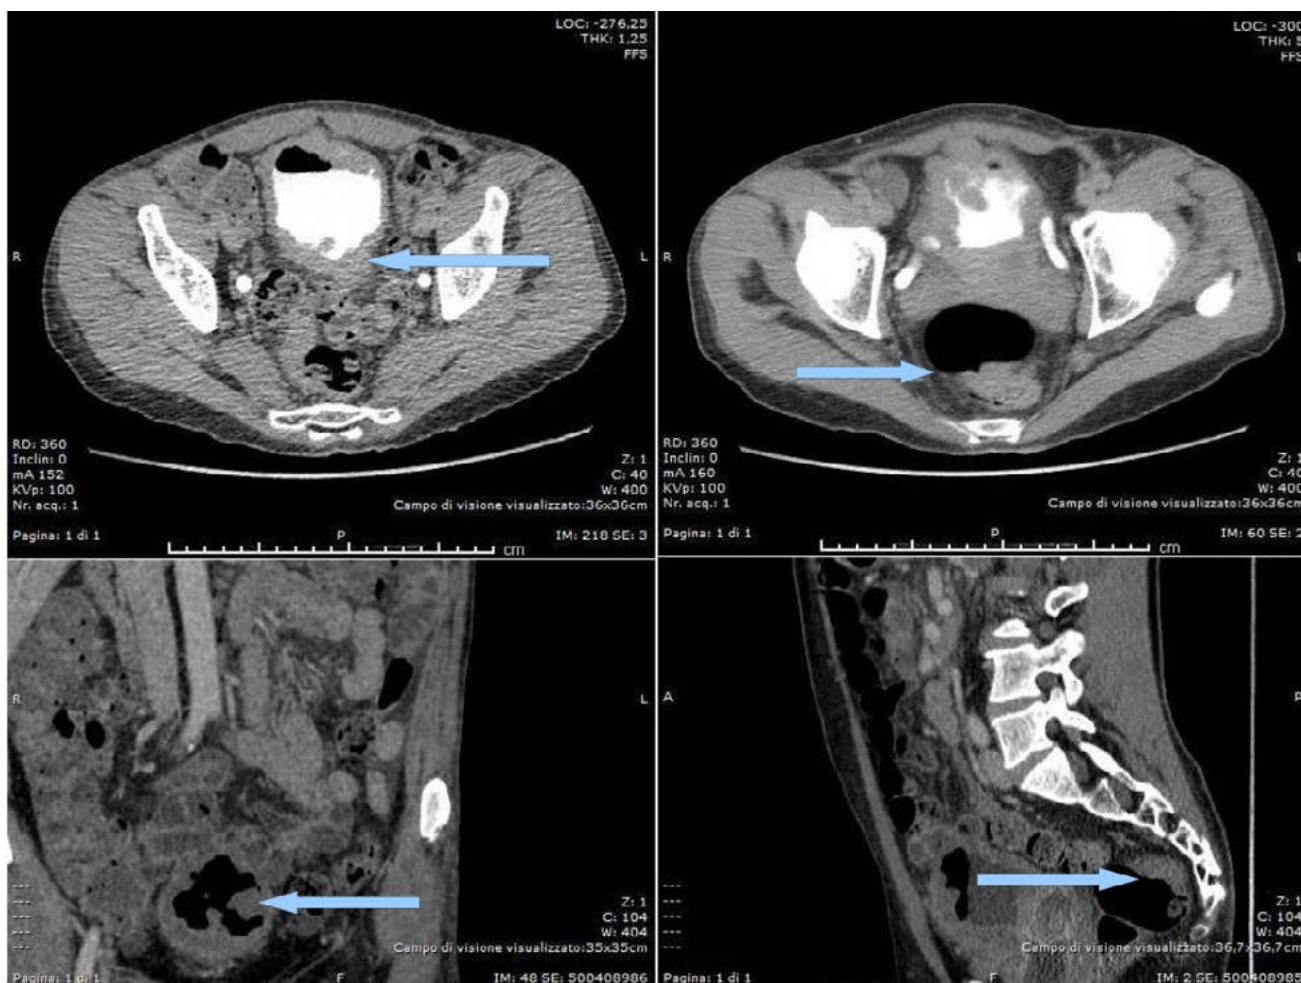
CT scan diffuse involvement of the bladder with uneven thickening of the entire wall.
